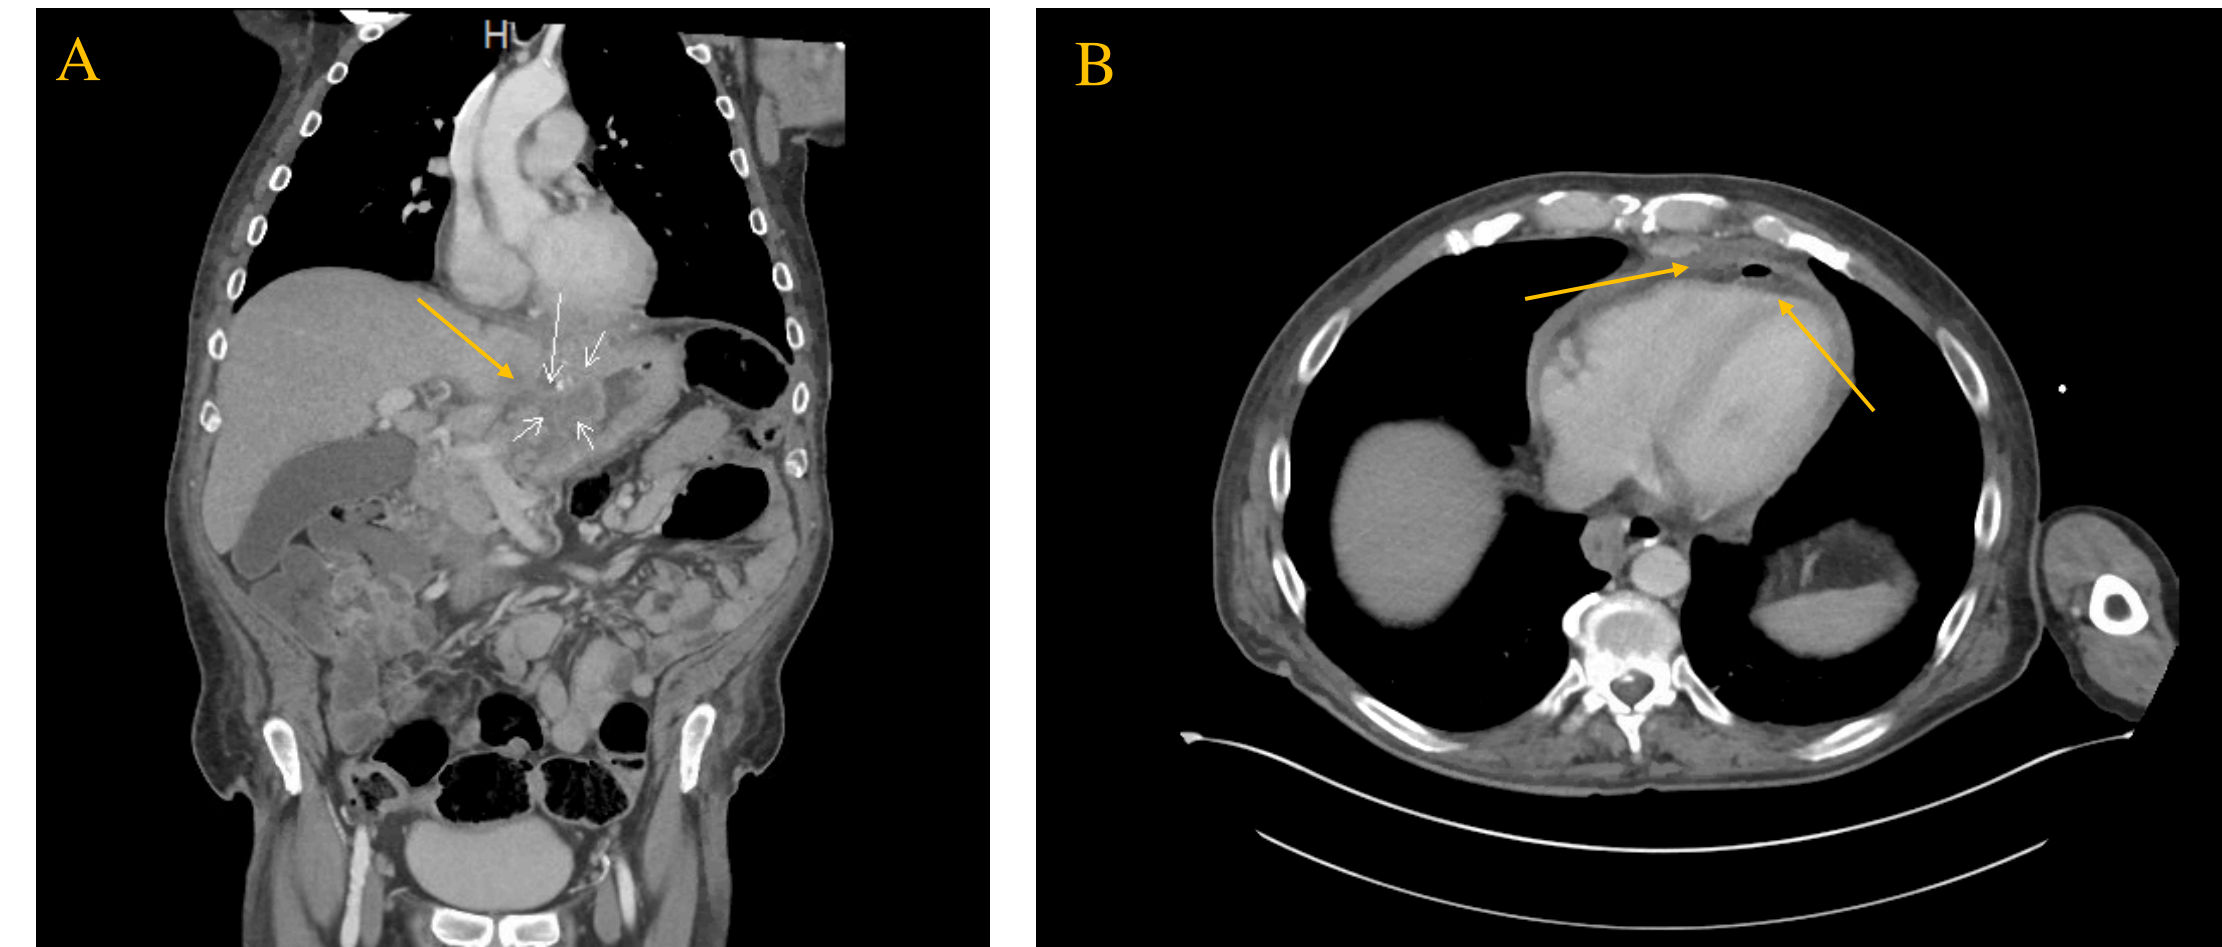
CT abdomen and pelvis with IV contrast (6/23/2022). (A) Arrows indicate perforated marginal ulcer at the level of the gastrojejunal anastomosis with the formation of a walled off intra-abdominal abscess tracking through diaphragm. (B) Arrows indicate the formation of a pericardial abscess with pneumopericardium.
